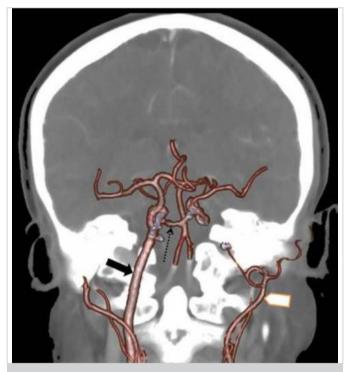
On the coronal contrast-enhanced computed tomography-angiographic fusion image, the internal carotid artery on the right is patent (black arrow) and has a tortuous appearance. The internal carotid artery is not observed on the left. The external carotid artery (short white arrow) is seen on the left. Furthermore, the aberrant arterial structure originating from the distal right internal carotid artery and extending to the left (aberrant left internal carotid artery, dotted black arrow) calls attention
